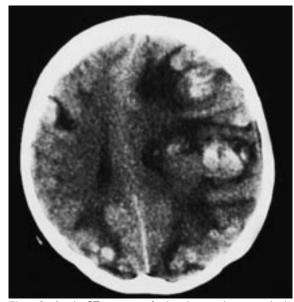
Axial CT image of the brain shows multiple haemorrhagic secondaries with midline shift to the right.
